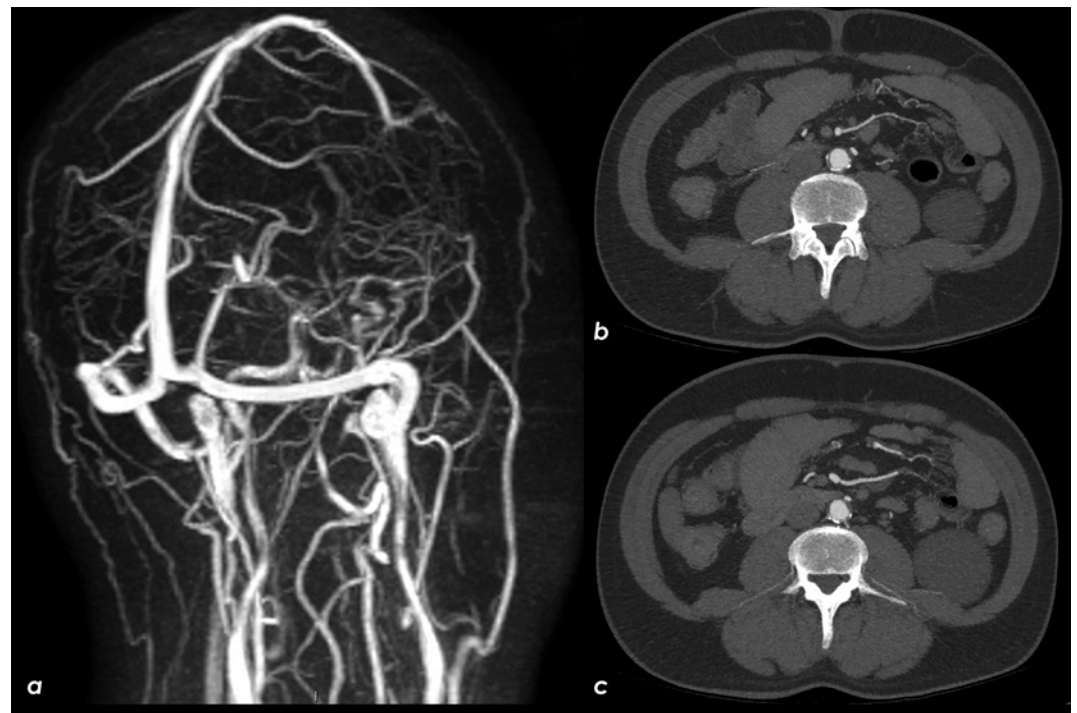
Brain MRI and abdominal CTA in follow-up. The right lateral dural venous system was patent in the MRA (a, time of flight reconstruction). Aortic CTA shown the disappearance of the floating hypodense structure previously seen and adherent to a crescent-shaped atheroma (b and c, axial MIP reconstructions).
